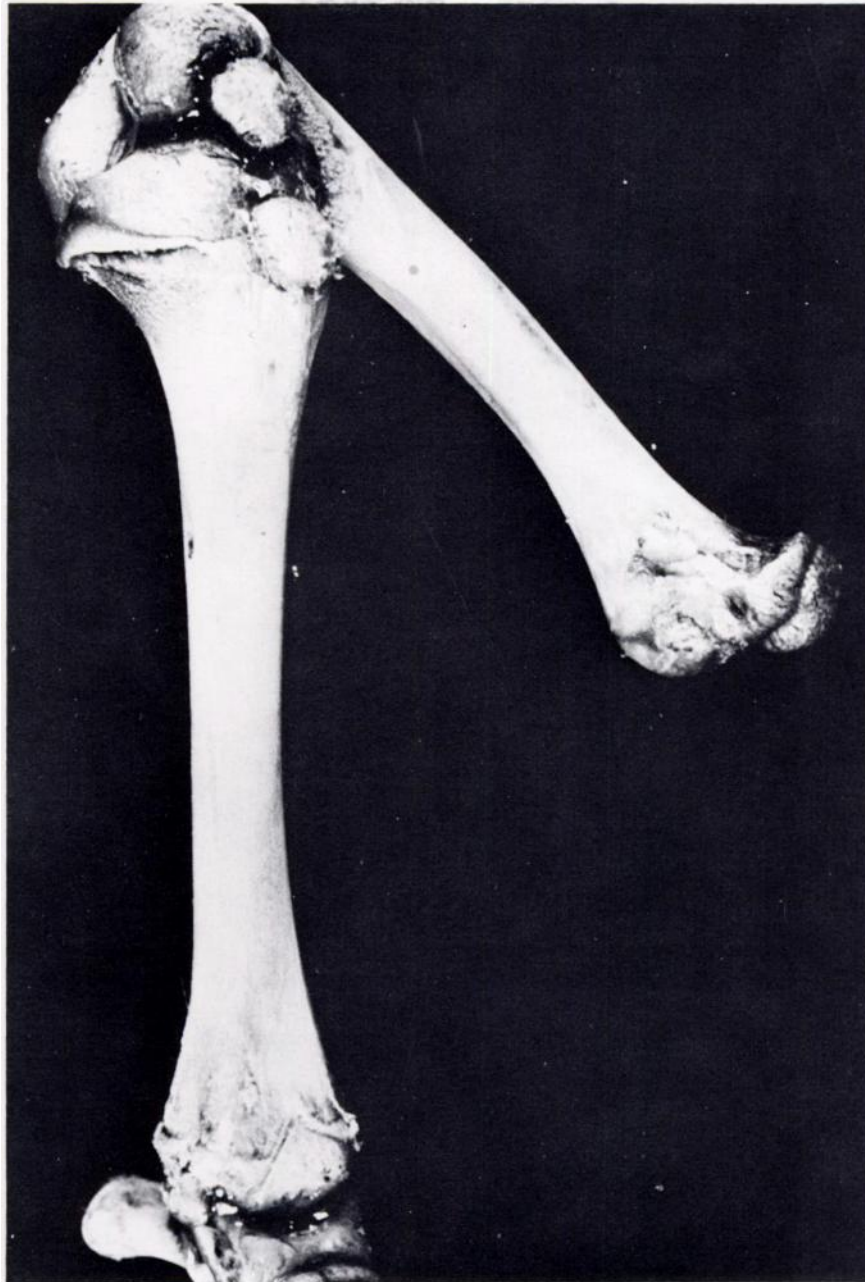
The bones of the right rear limb were reconstructed for comparison to the radiograph.
